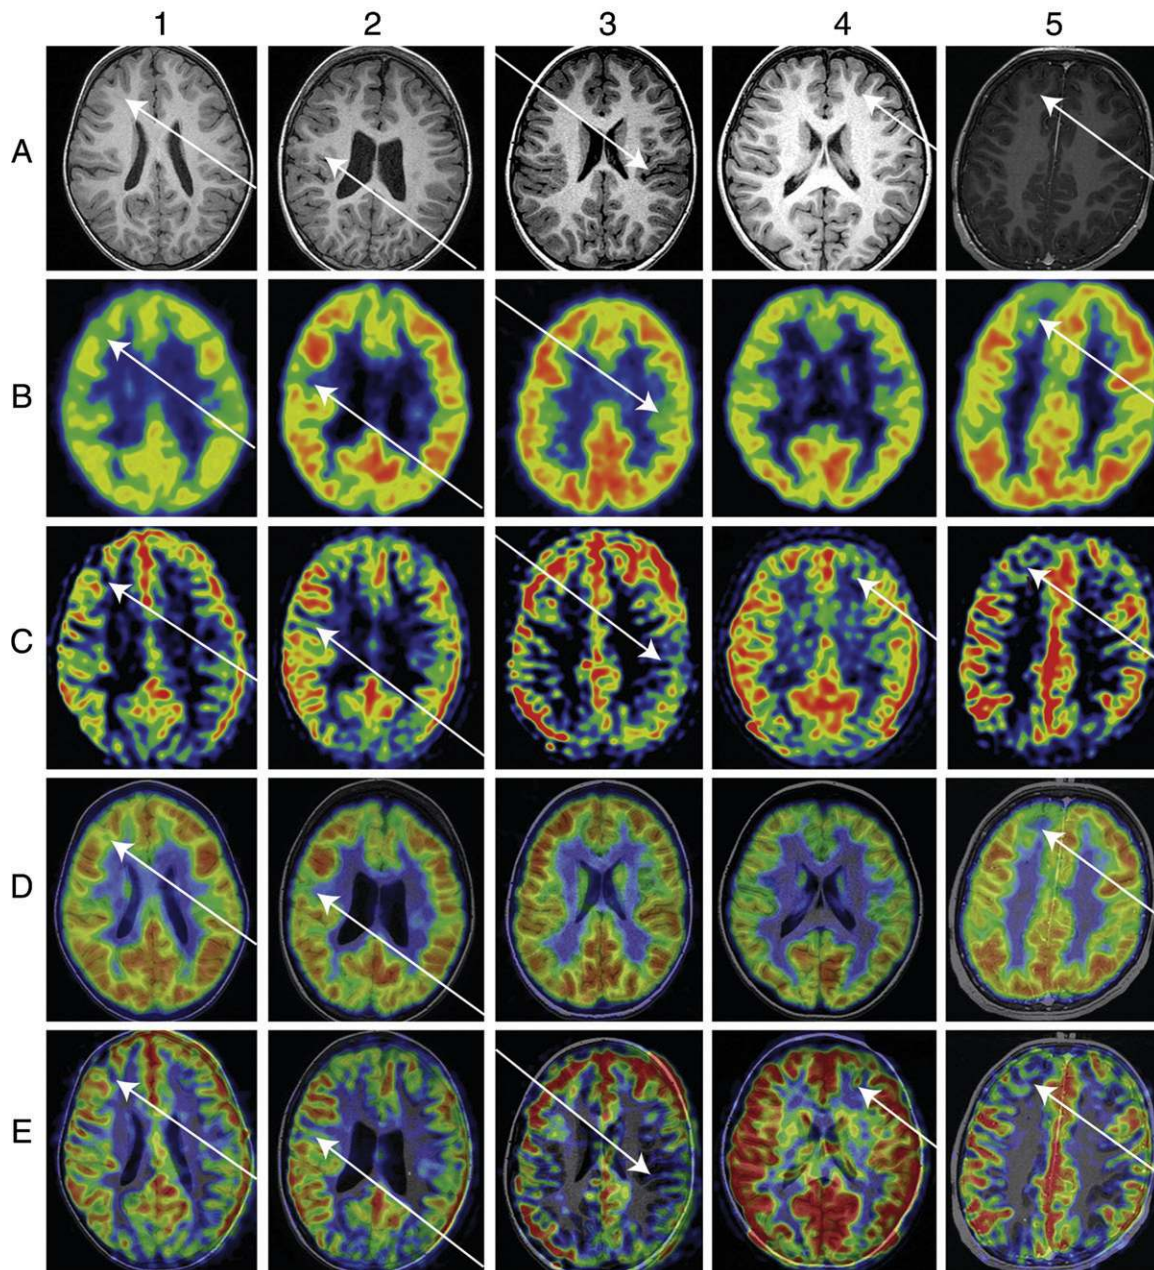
Comparison of ASL MR imaging and FDG PET in epilepsy. Each column represents imaging studies of a single patient. *A*, Preoperative axial T1-weighted MR images. *B*, Raw FDG PET images. *C*, Raw PASL CBF maps. *D*, Image fusion of T1-weighted MR imaging and FDG PET. *E*, Image fusion of T1-weighted MR imaging and PASL. Arrows indicate regions of focal cortical dysplasia that are epileptogenic. Numbers 1–5 refer to different patients. (Reprinted, with permission, from reference 80.)
